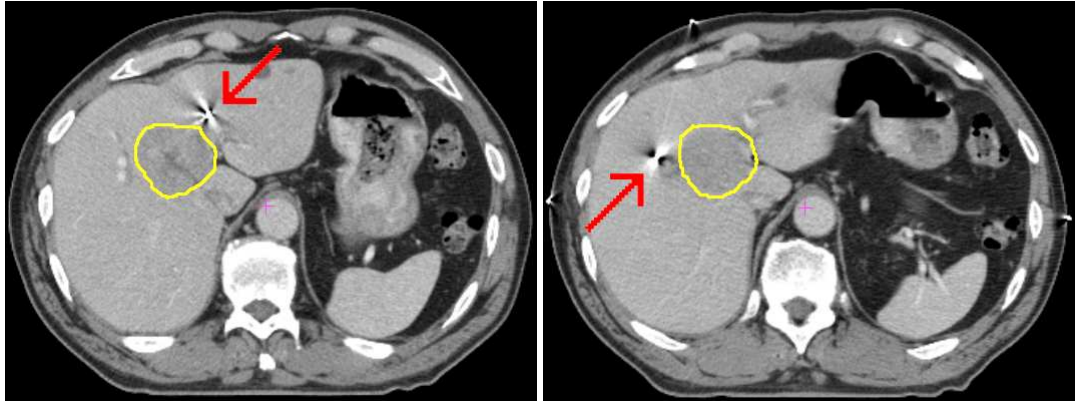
Two slices of a CT scan. The tumor contour is marked yellow. One clip in each image is visible as a thick white mark outside of the contour as indicated by the red arrow. The pink cross marks the center of the image.
